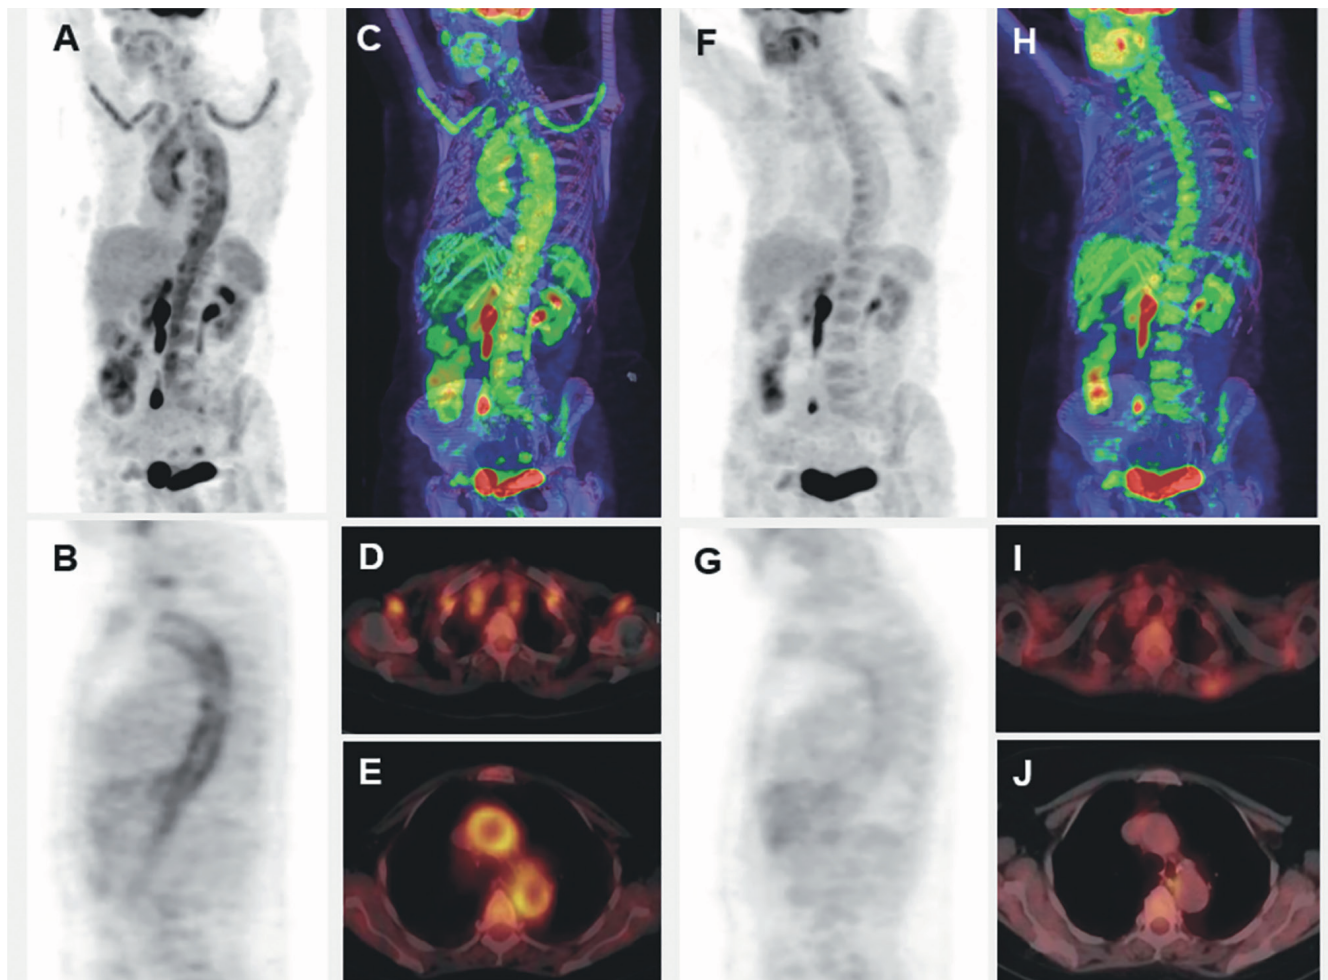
Baseline PET (A, B) and fused PET/CT images (C-E) of a 71 year-old-woman, showed an intense FDG uptake along the thoracic and abdominal aorta, brachiocephalic trunk, subclavian and axillary arteries (TVS: 3; TBR at the thoracic aorta: 2.36). Follow-up PET (F, G) and fused PET/CT images (H-J) performed 24 months after tocilizumab showed the disappearance of uptake at the brachiocephalic trunk, subclavian and axillary arteries and an important decrease of aortic uptake (TVS: 1; TBR: 1.37). (TBR: target-to-background ratio; TVS: total vascular score).
